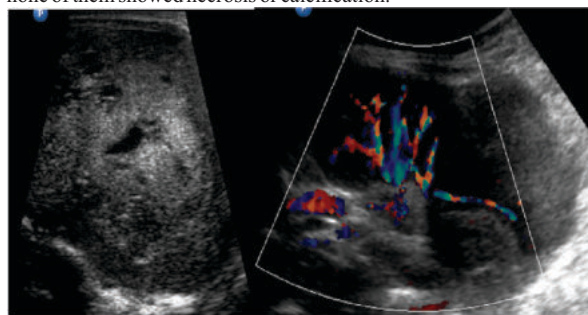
Hemangioendothelioma of liver – A 3 day old male child presented with symptoms of congestive heart failure. Ultrasound of the abdomen revealed an echogenic mass lesion in the liver with few cystic areas. Doppler shows high velocity arterial flow throughout the lesion. Serum AFP was 75000 ng/ml.
